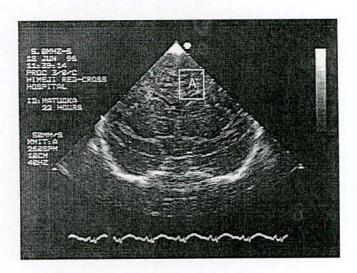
Corpus callosum region is indicated by block A in ultrasonogram image of anterior coronal section of a neonate.
